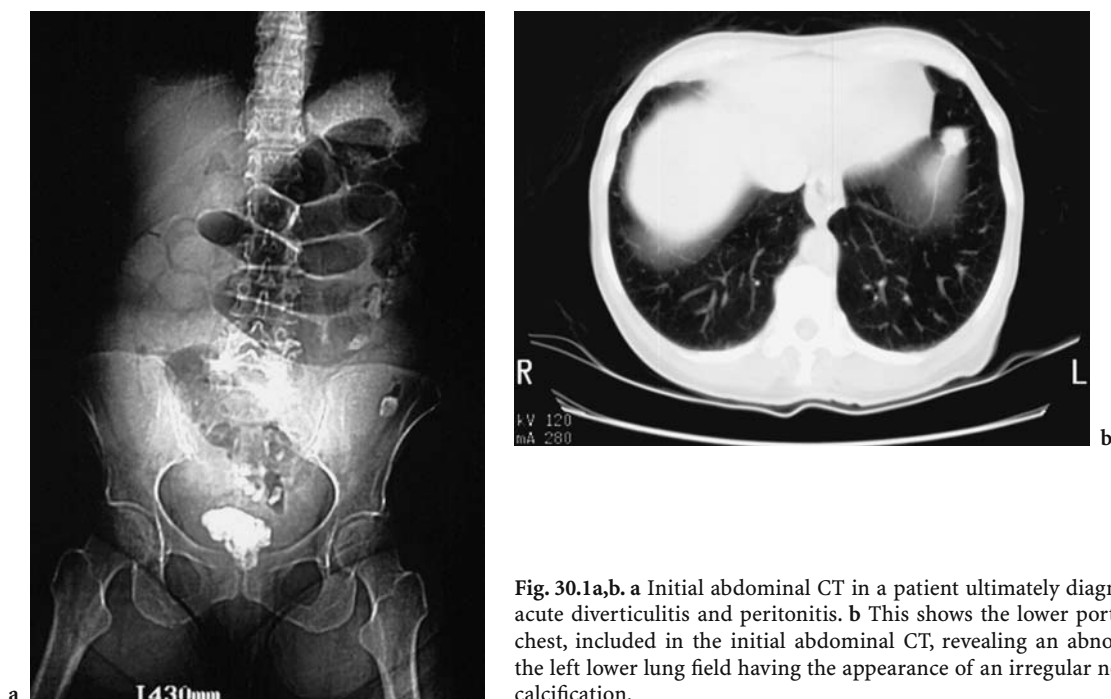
a Initial abdominal CT in a patient ultimately diagnosed with acute diverticulitis and peritonitis. b This shows the lower portion of the chest, included in the initial abdominal CT, revealing an abnormality in the left lower lung field having the appearance of an irregular nodule with calcification.
